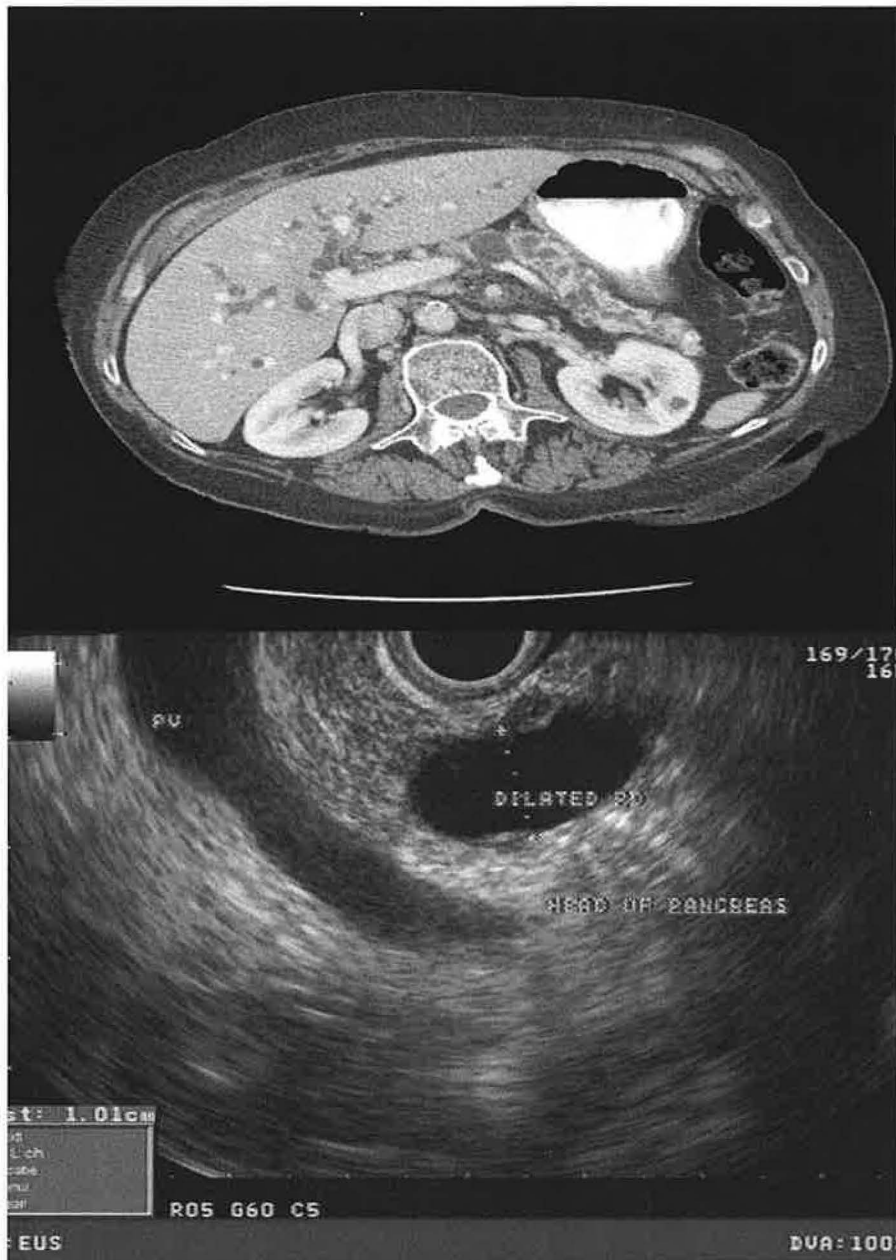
Massively dilated main pancreas duct, with side-branch dilatation on the CT scan image on top. Representative image of a dilated main pancreas duct by EUS below. Note that the pancreas duct is as wide as the portal vein (PV). Courtesy J. Sreenarasimhaiah.
